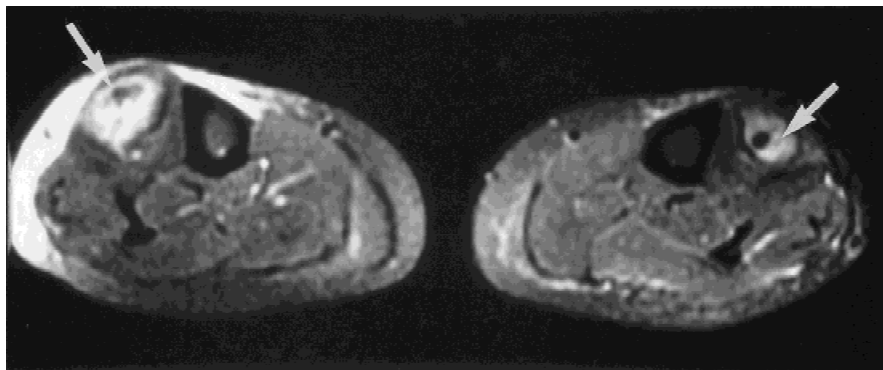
Case 2. Magnetic resonance imaging scan of lower extremities (legs), showing abnormal T2 signal and enhancement in tibialis anterior muscles bilaterally (arrows). There is enlargement of these muscles and central area of non-enhancement consistent with necrosis.
